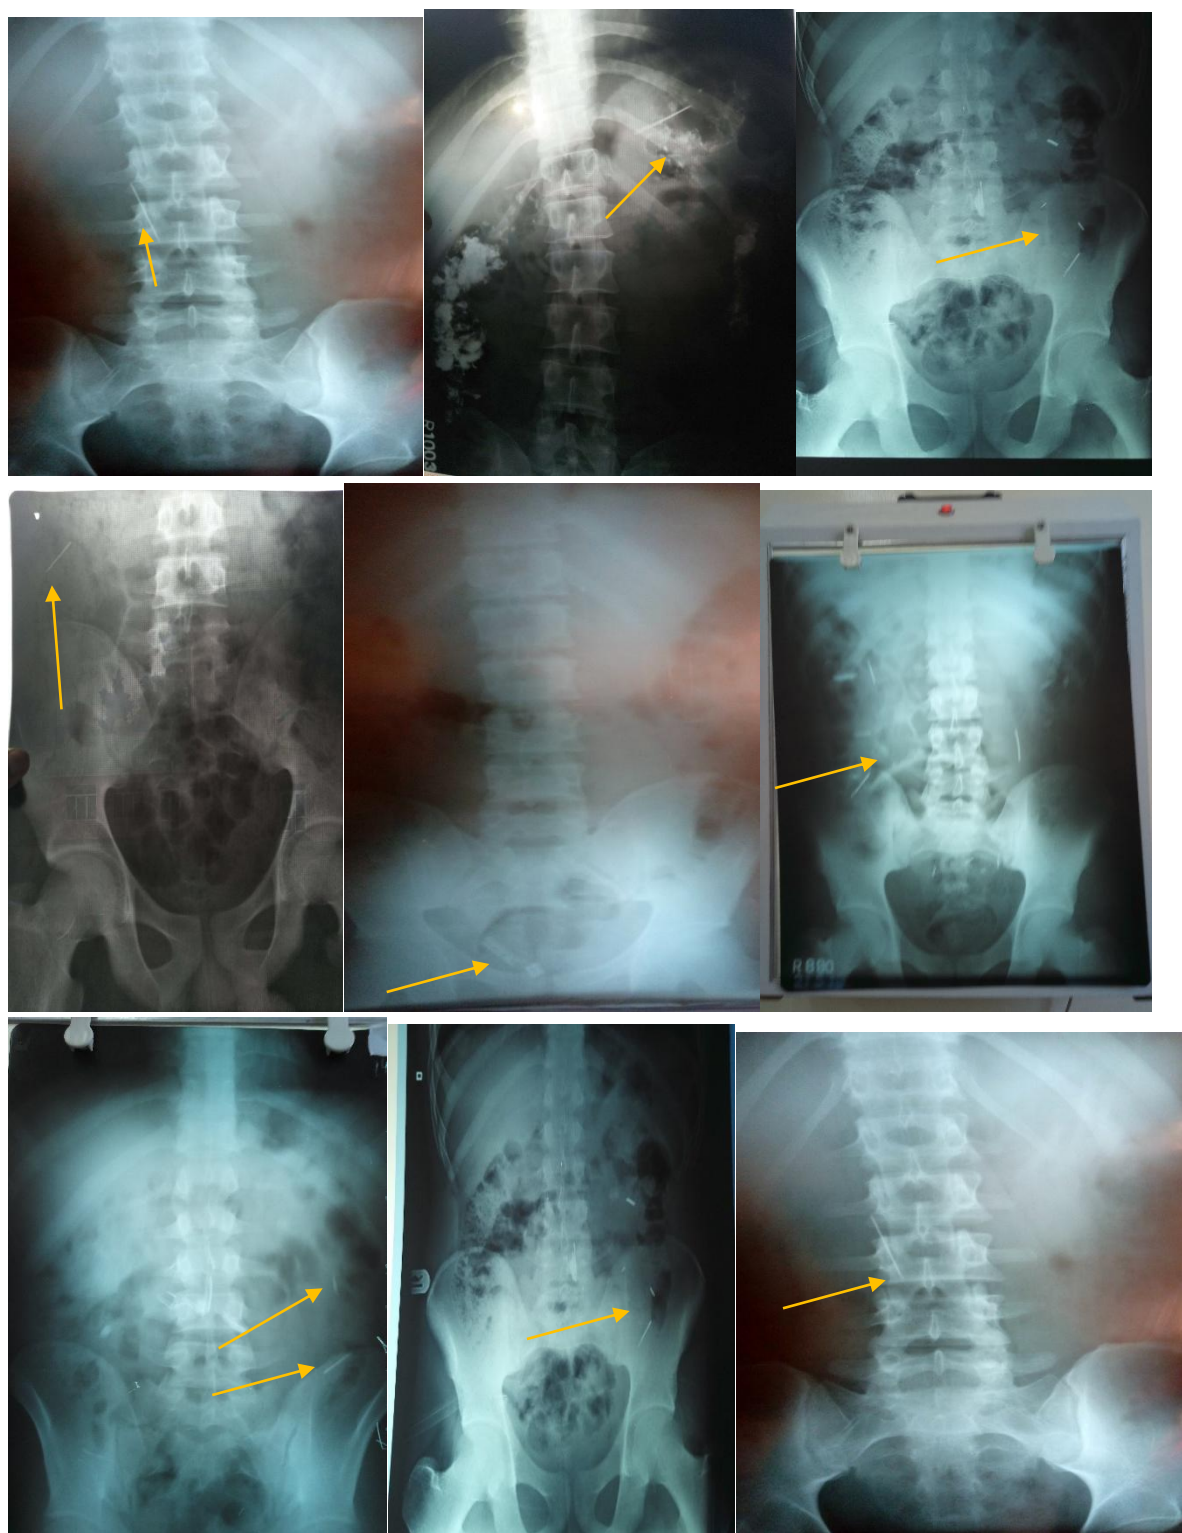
Xrays of abdomen of different cases indicating radiopaque sharp foreign bodies within bowel
